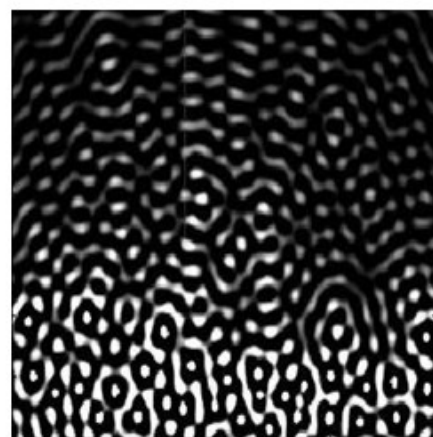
Acoustic markers are presented, which are ultrasound fingerprints.
